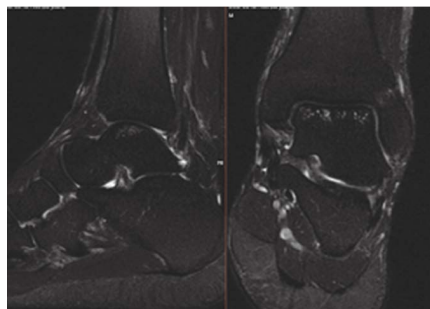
Left Ankle MRI April 2021
